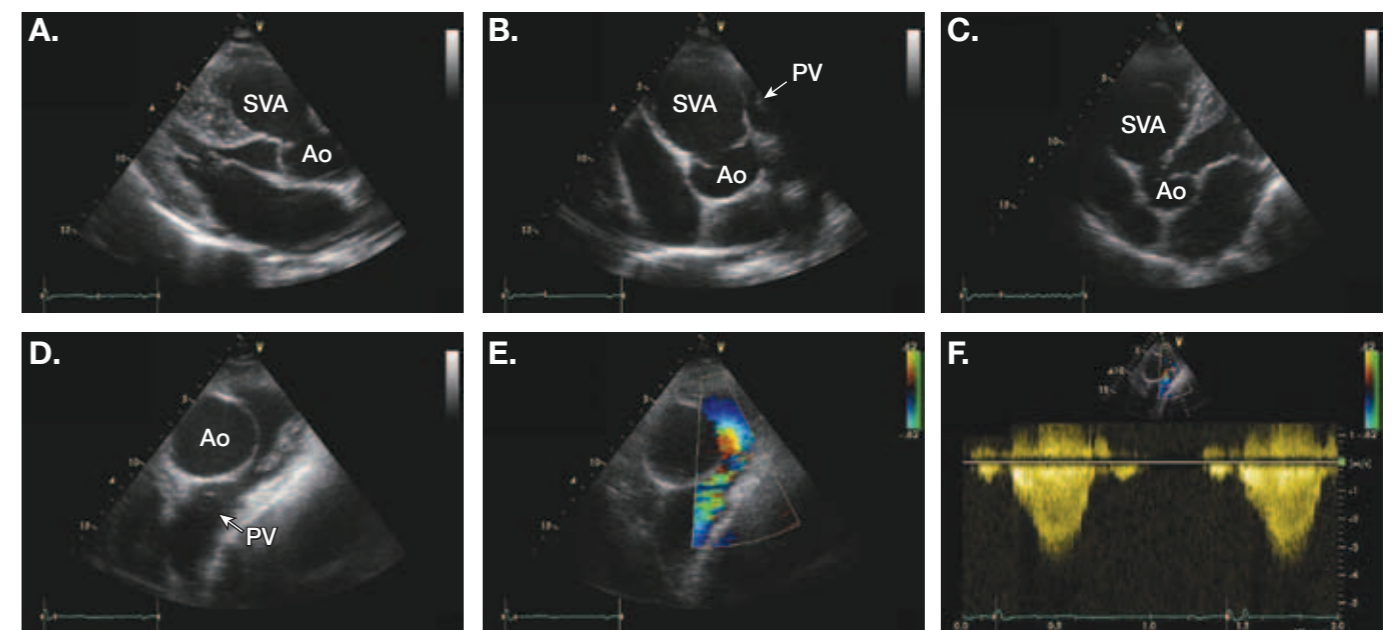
A large right sinus of Valsalva aneurysm (SVA) is shown. Images are recorded from the parasternal long axis view (A), the parasternal short axis view (B), the apical 5-chamber view (C) and a high parasternal short axis view (D). Right ventricular outflow tract (RVOT) obstruction due to the significant protrusion of this aneurysm into the RVOT is also apparent (D). Colour Doppler imaging (E) confirms the presence of turbulent flow across the RVOT. The peak velocity across the RVOT was approximately 3 m/s, yielding a pressure gradient of 36 mm Hg (F). Ao = aorta; PV = pulmonary valve.
